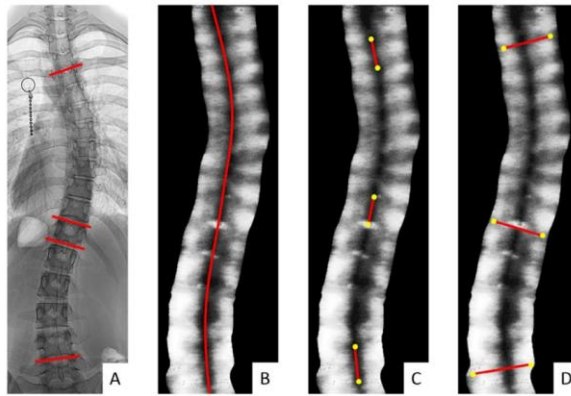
a) Coronal Cobb angle measured by X-ray, b) automatic spinous process angle measurement, c) manual spinous process angle measurement, and d) manual transverse process angle measurement (Brink *et al.*, 2018)
